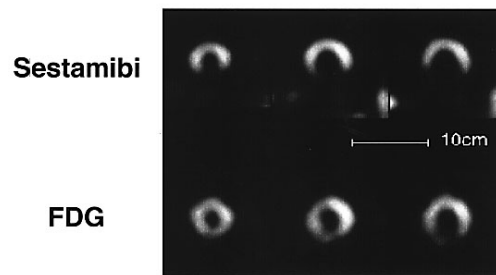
^{99m}Tc -sestamibi (*upper*) and ^{18}F -FDG SPECT (*lower*) images acquired simultaneously from a patient with inferior myocardial infarction. A reduced perfusion associated with preserved ^{18}F -FDG uptake (flow-metabolism mismatch) is noted.
